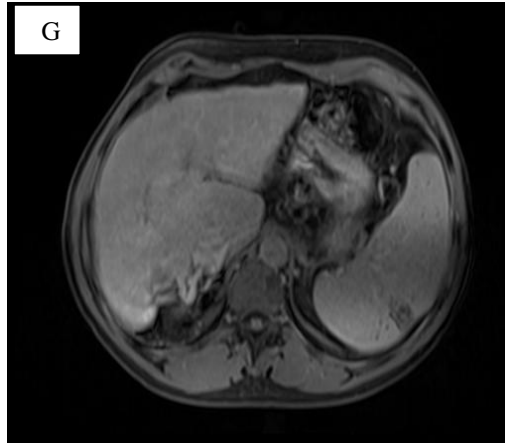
(A) Coronal T1WI, (B) Coronal T2WI, (C) DWI, and (D) ADC Map were found by MRI. Phases (E) Arterial (F) Portal and (G) An enlarged spleen was discovered by delayed phase, measuring 15.3 cm at its widest point, with an upper polar focal lesion that had poor signal in both T1WI and T2WI. Free diffusion was seen in the lesion, with a mean ADC value of 1.5×10^{-3} sec/mm². Throughout the whole research, the lesion didn't exhibit any post-contrast enhancement. Based on the MRI results, the diagnosis of splenic infarction was made.
